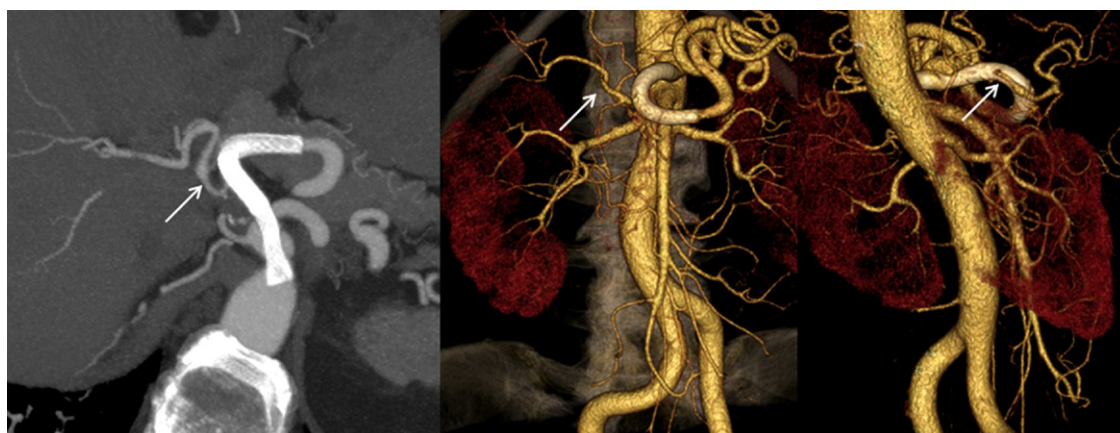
Left, Computed tomography angiography image 12 months after the procedure shows the patency of the stents and of the parent vessels (*arrows* show the common hepatic artery). Middle and Right, Volume-rendered reconstructions highlight the patency of the hepatic artery.
